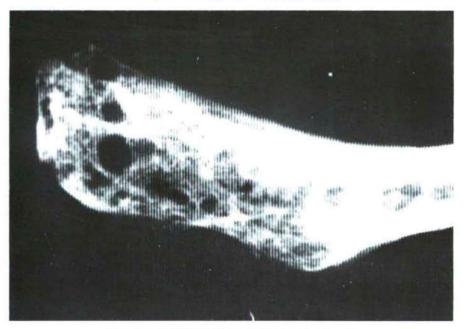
Lytic foci on the X-ray photograph of the rib Finding Nr. 11567, grave Nr. 305, adult female
